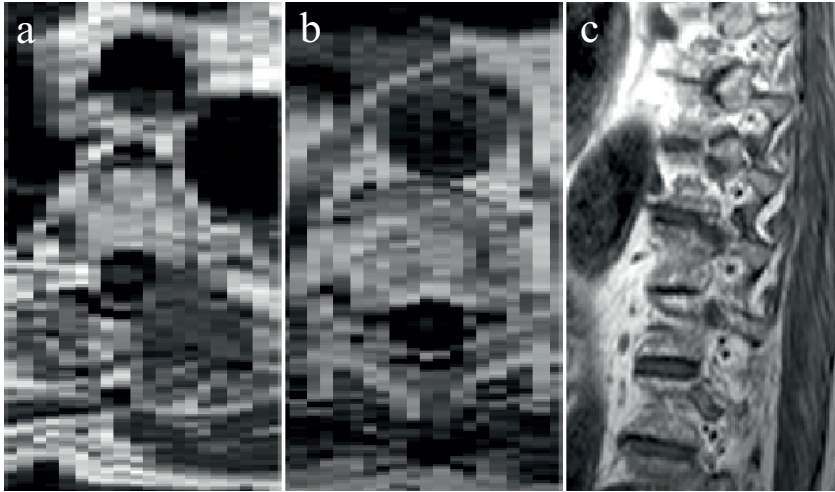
Two reconstructed axial (a and b) and one native sagittal slices (c) of a clinical routine T_1 -weighted MRI scan demonstrate the difficulty in distinguishing vertebrae from adjacent structures due to the partial volume effects (PVE) caused by high anisotropy. With large sagittal slice spacing, this becomes particularly pronounced at the lateral ends of the vertebrae.
